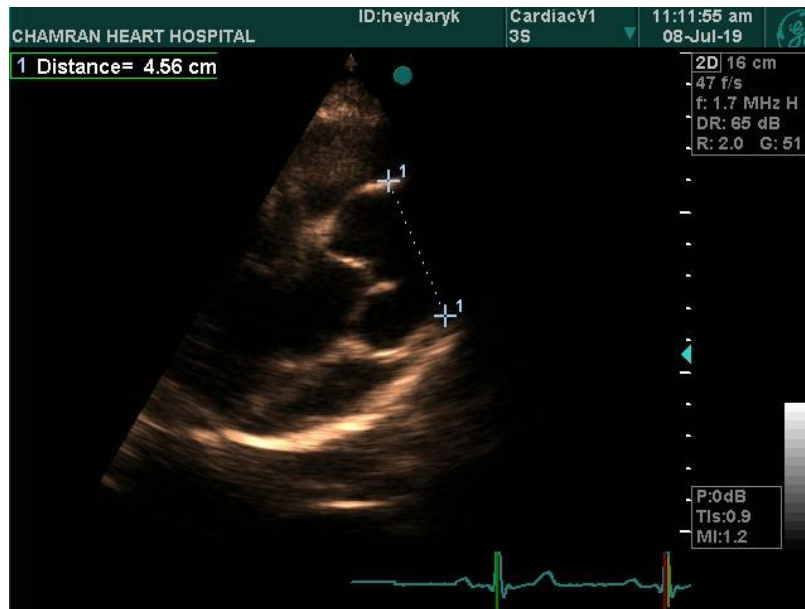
Echocardiography findings show that A) the size of the aortic annulus is 3.50 cm, B) the size of the sinus of Valsalva is 5.06 cm, C) the size of the sinotubular junction is 4.56 cm, and D) the size of the ascending aorta is 3.48 cm.
